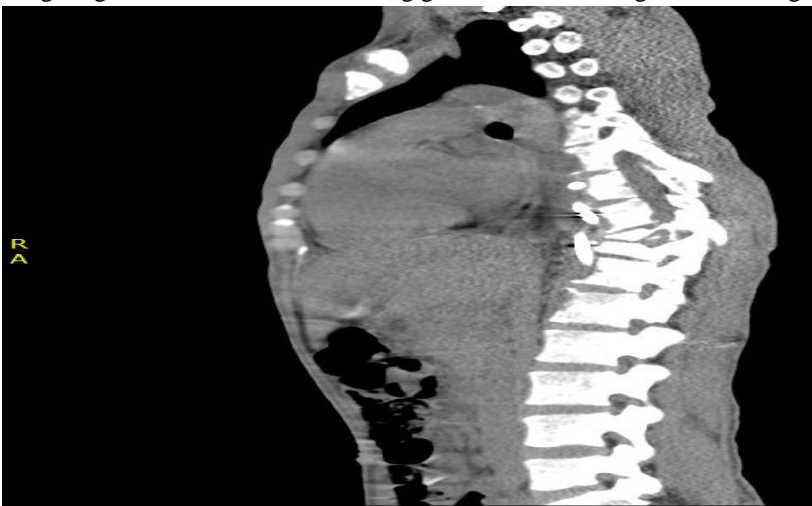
Post-drainage sagittal reformat of CT showing good abscess drainage and unchanged bony destruction.
